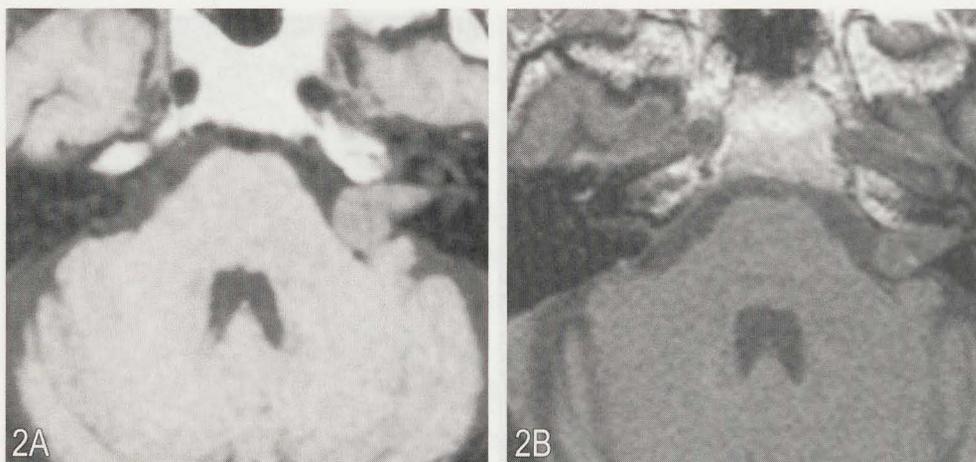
Patient 2. MRI-scans in the axial plane; the images show the largest surface of the tumor, initially (A) and after 10 years follow-up (B). See also Table 3.
